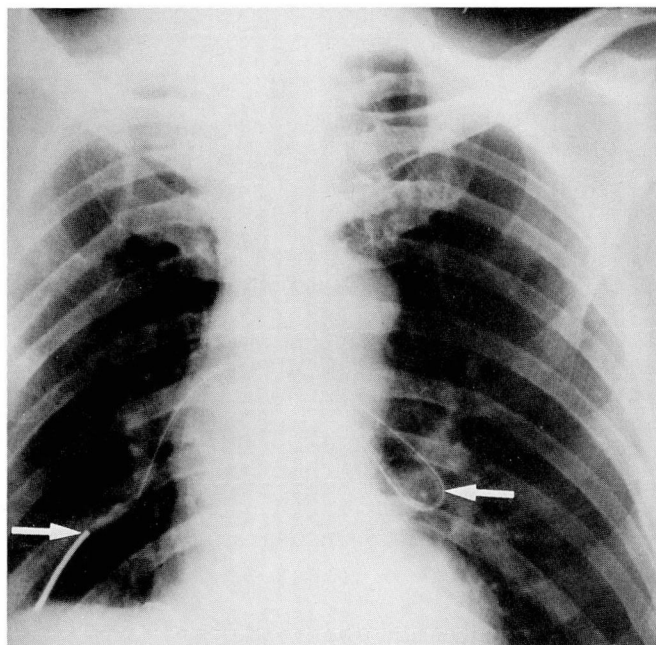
Chest radiograph reveals endobronchial placement of a Corpack feeding tube (arrows) as a cause of wheezing in a patient with bilateral vocal cord paralysis.
